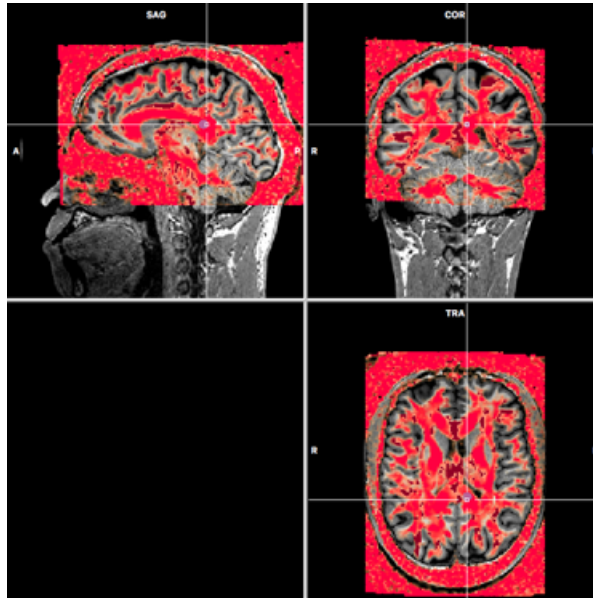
Principal direction map registered on the patient anatomical MRI.
